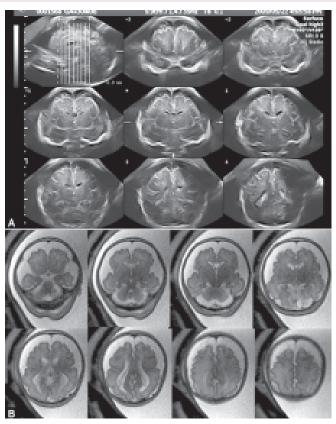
Tomographic ultrasound imaging (TUI) and MR imaging of hydrocephalus at 21 weeks of gestation. (left) Sagittal, axial and coronal parallel cutting sections by sonography well demonstrate ventriculomegaly. Partial agenesis of the corpus callosum is detected in the midsagittal section. (right) MRI images of the same case. No significant difference between sonography and MRI
